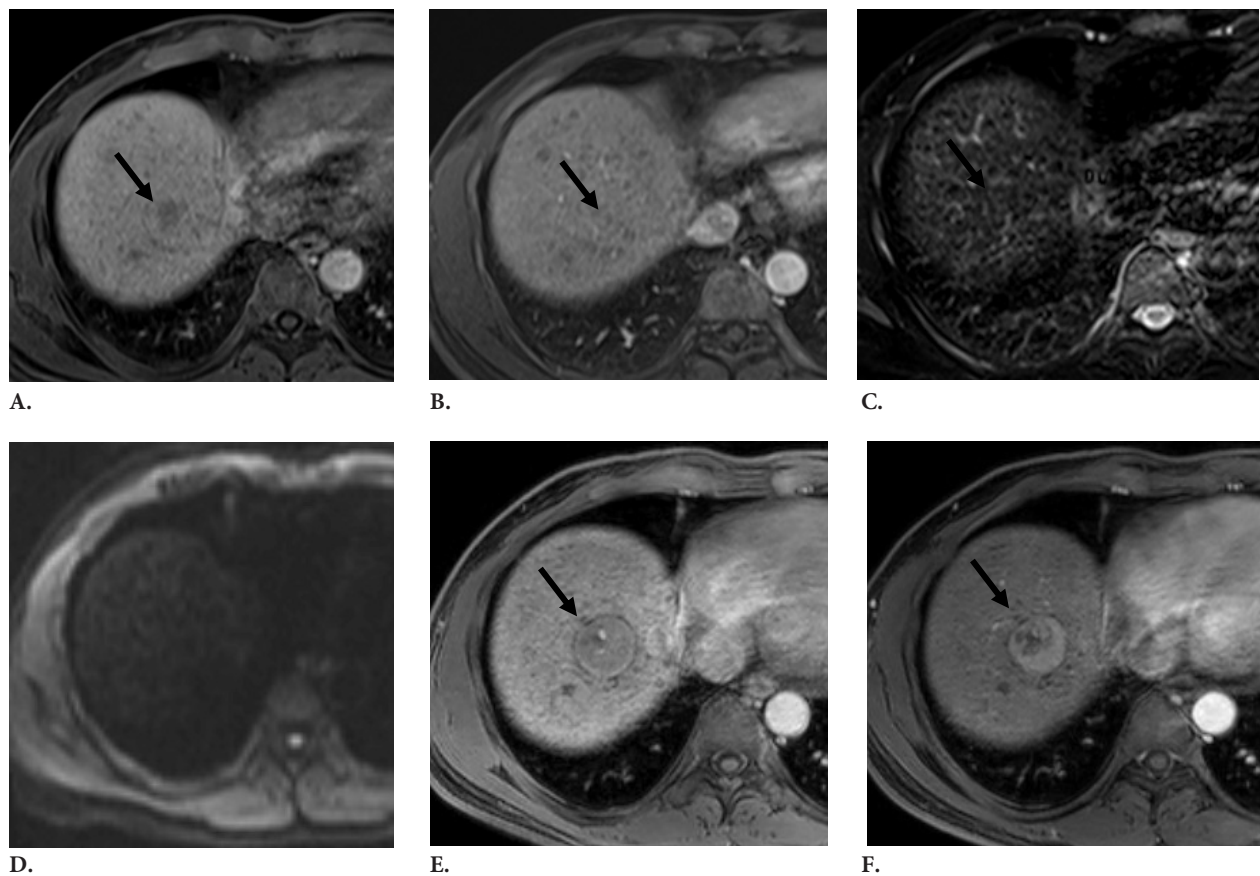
A 53-year-old male with HCV cirrhosis. (A) Axial gadoxetic acid-enhanced 20 minute HBP image showing a hypointense nodule, initial diameter of about 1.7 cm. (B) Axial arterial phase showing no arterial enhancing nodule at the same location. (C) Axial T2W image and (D) DW image ($b = 800 \text{ sec/mm}^2$) observed no hypersignal intensity. (E,F) Axial gadoxetic acid-enhanced MRI obtained later 9 months, the same nodule showed increased in diameter to 3.1 cm. measured in (E) hepatobiliary phase image. (F) Arterial phase showing hypervascularization.
